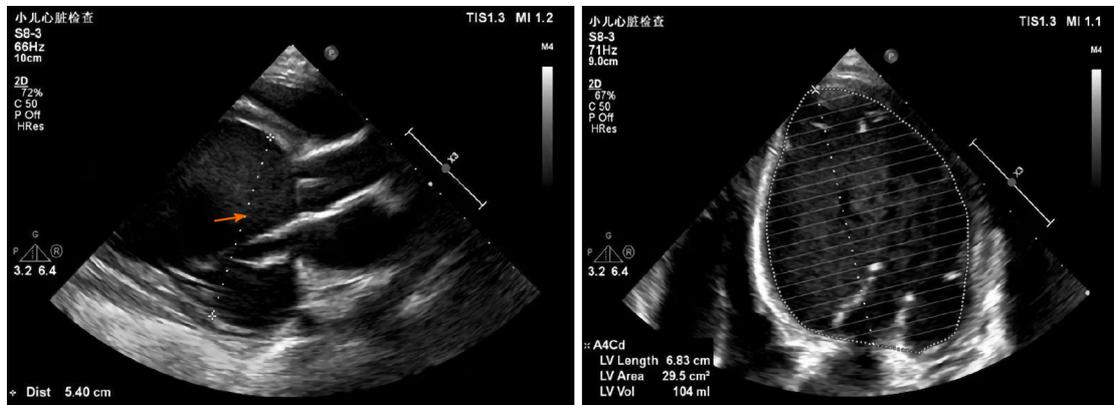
Echocardiogram. The heart chamber sizes showed an enlarged heart, especially the left heart.
